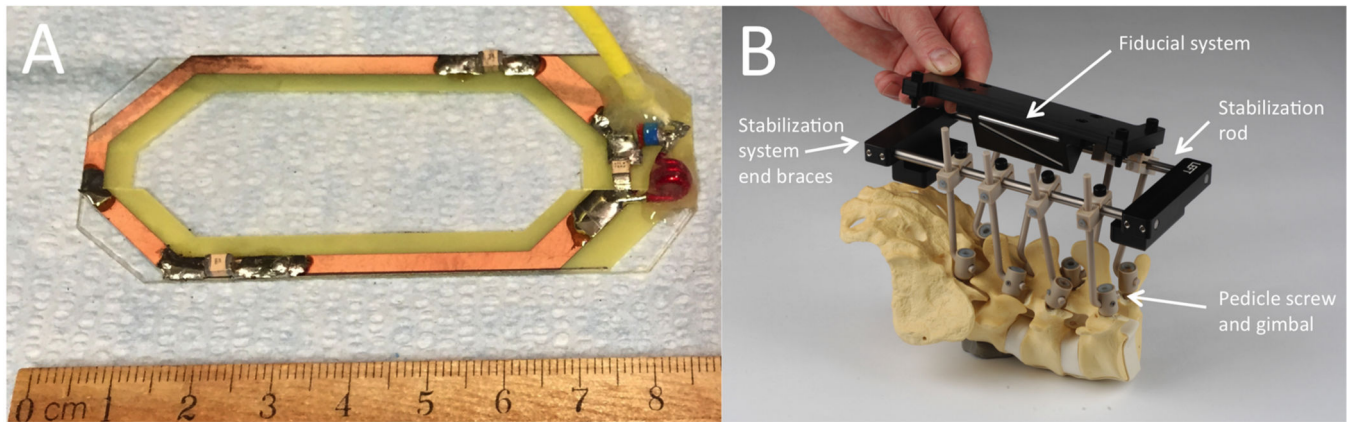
Magnetic resonance imaging components. (A) Single coil radio frequency-receive only MRI antenna designed for placement within the surgical site. (B) The frame is stabilized using polyether-ether-ketone screws, gimbals, and connection rods that attach the spine to the stabilization platform. The stabilization platform is comprised of titanium rods and polyoxymethylene end braces. The end braces contain mounting points to allow attachment of frame components (i.e., Magnetic resonance imaging fiducial system, stereotactic platform).
